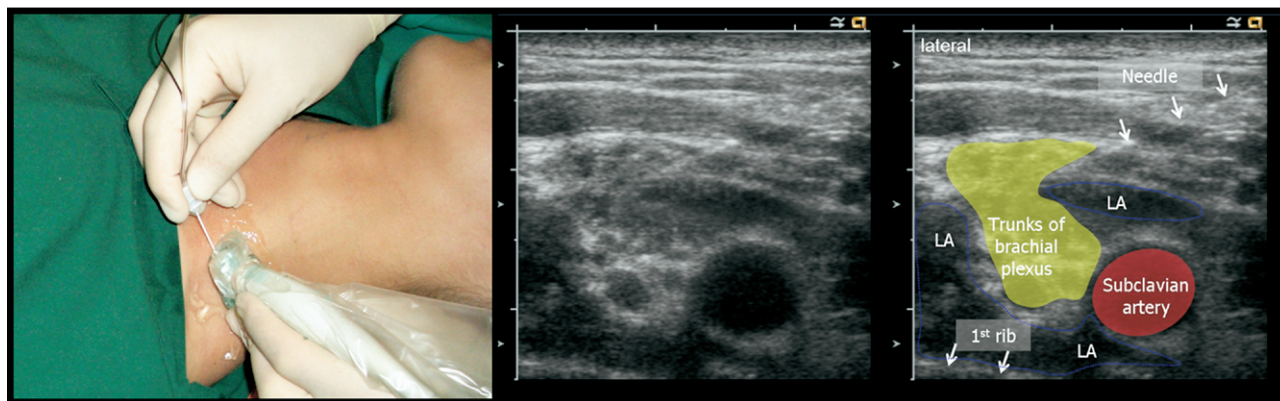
(Left panel) In-plane approach to supraclavicular block. (Middle and right panels) Corresponding sonogram showing the trunks of the brachial plexus, subclavian artery, first rib, block needle, and injected local anesthetic distribution (LA). In this example, a 22-gauge, 5-cm Stimuplex needle (B. Braun, Melsungen, Germany) was used.
